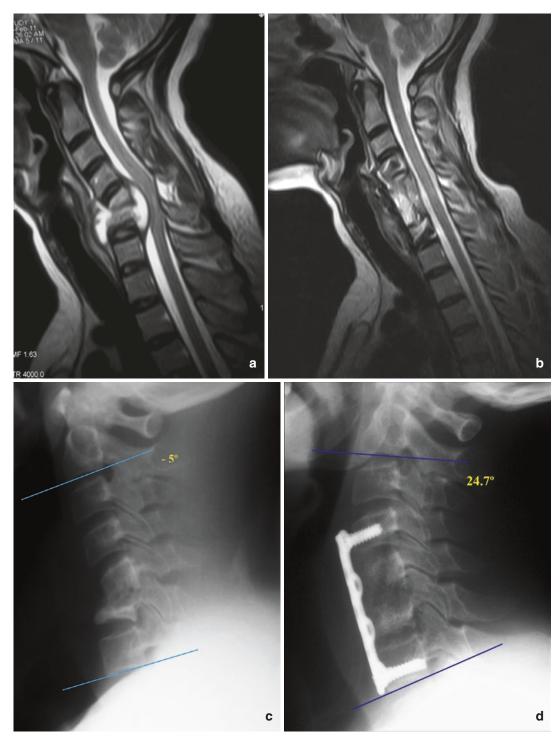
A 30-year-old female with cervical spine tuberculosis (TB) treated by surgical decompression and fixation: (a) preoperative sagittal T2-WI magnetic resonance imaging (MRI) showed destruction of C5-C6 vertebral bodies with epidural collecting pus compressing the cord at that level. (b) Postoperative sagittal T2-WI MRI
